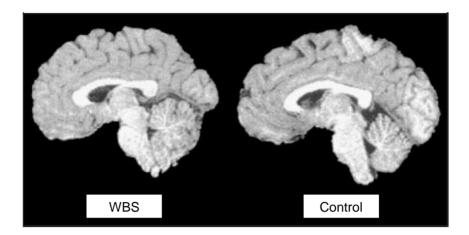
Qualitative cerebral shape differences between a WBS individual and an ageand sex-matched control using MRI. The image demonstrates the parieto-occipital lobe reduction. Note the reduction in total brain size. From⁶⁵.
